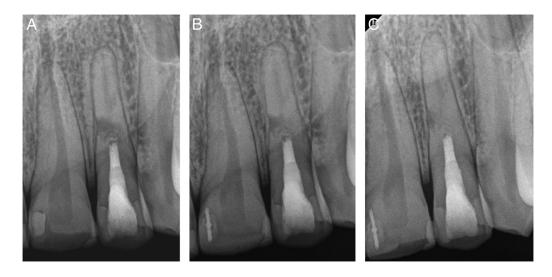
The periapical radiographs after (*A*) 1, (*B*) 2, and (*C*) 3 years reveal that the healing process has progressed with reparative hard tissue formation inside the resorptive cavity.
